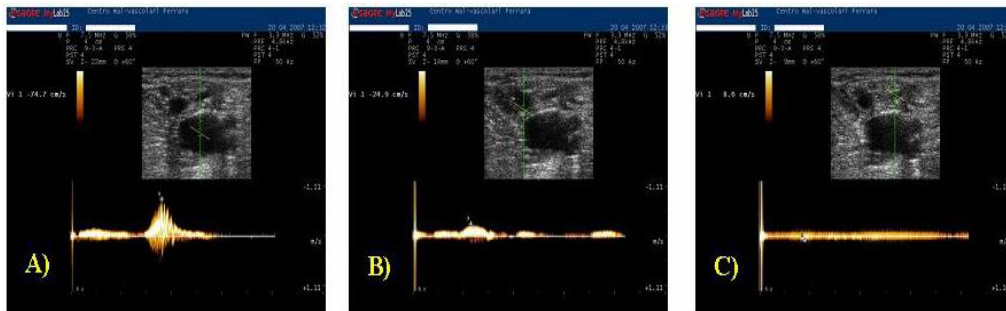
Decreasing velocities from N1 to N3, due primarily to the lesser transfer of energy from muscle contraction to the superficial vessels. In A the Doppler sample is placed in the femoral vein (N1), in B in the saphenous vein (N2), and in C in the tributaries of the sapheno-femoral junction (N3).
